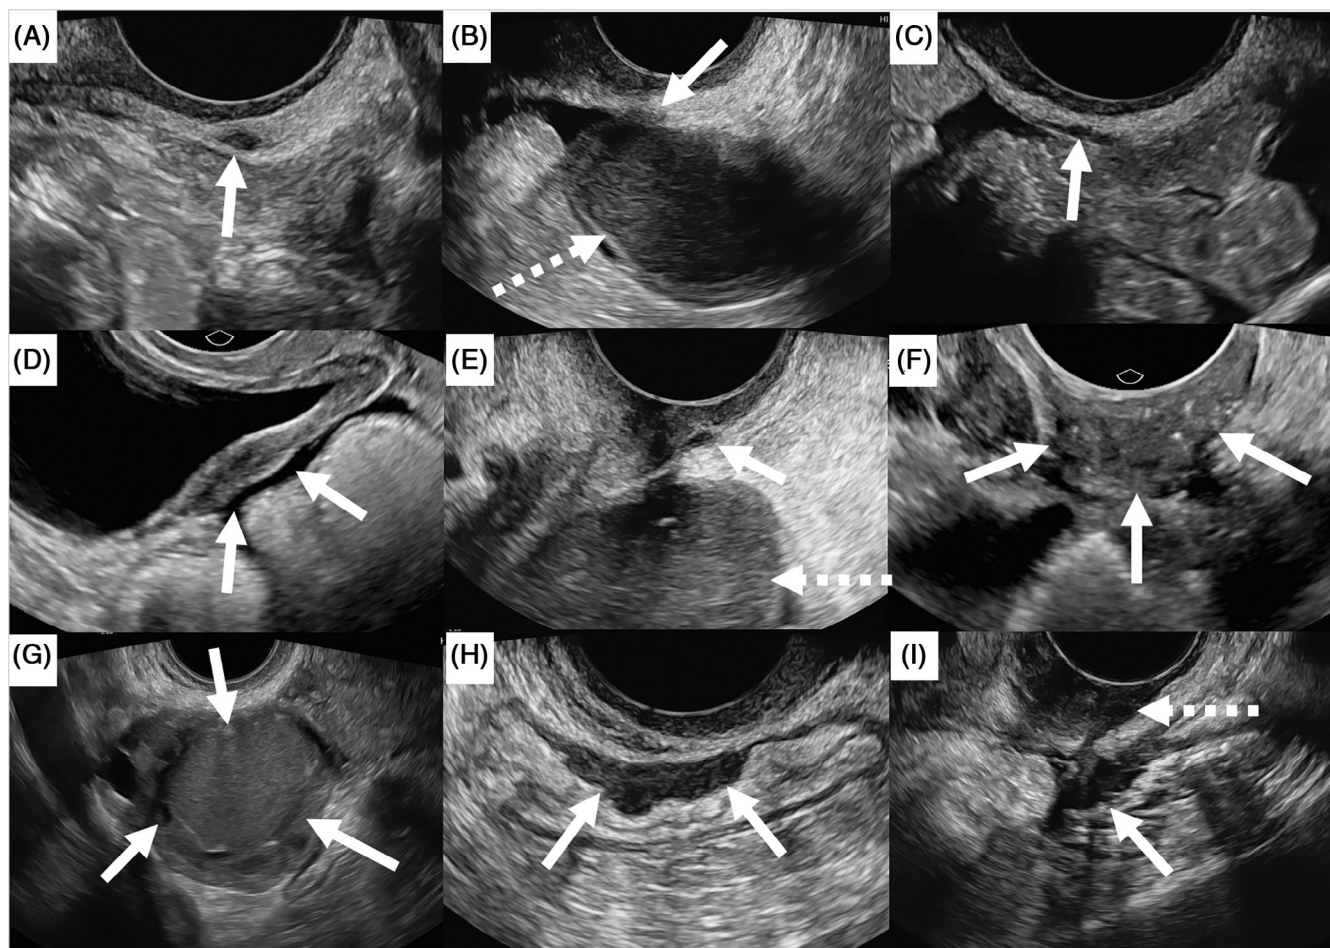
Various example of deep endometriosis as it can appear on transvaginal ultrasound at various anatomical locations as demonstrated by the white arrows. (A) Left uterosacral ligament nodule. (B) Left uterosacral ligament nodule. Note how this nodule is abutting an endometrioma within the left ovary (dashed arrow). (C) Right uterosacral ligament disease. (D) Bladder nodule presenting as fusiform thickening within the posterior bladder wall. (E) A small nodule within the pouch of Douglas abutting the posterior vaginal wall. (F) A large nodule within the posterior vaginal fornix. (G) An ovarian endometrioma showing the classic appearance of a unilocular cystic lesion containing 'ground-glass' internal echoes. (H) A nodule of endometriosis within the rectosigmoid colon. (I) A nodule of endometriosis which is adherent to a nodule of endometriosis within the posterior vaginal fornix (dashed arrow) sonographically presenting as a diablo lesion.
